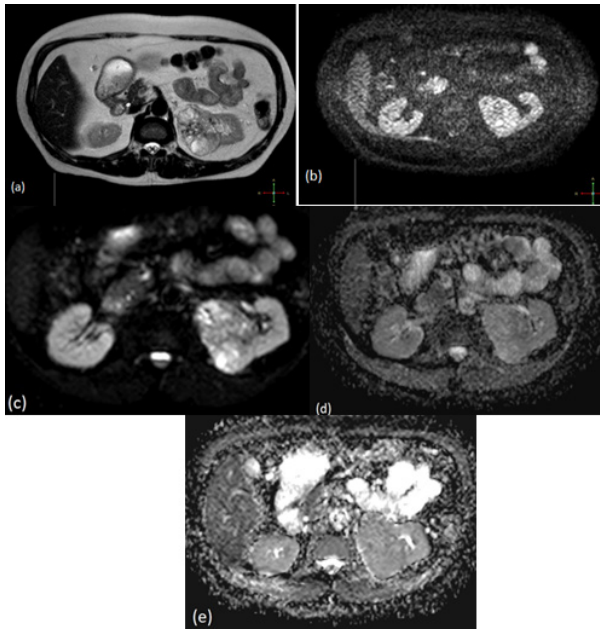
a-e). Clear cell RCC in a 56-year-old male patient. Heterogeneous hyperintense lesion containing areas of cystic necrosis in the left kidney on T2W images (a); showing restriction on DWI (b-e); the ADC values were measured as $1.68 \times 10^{-3} \text{ mm}^2/\text{s}$ at $b=1000$ (d) and $2.05 \times 10^{-3} \text{ mm}^2/\text{s}$ at $b=500$ (e)
